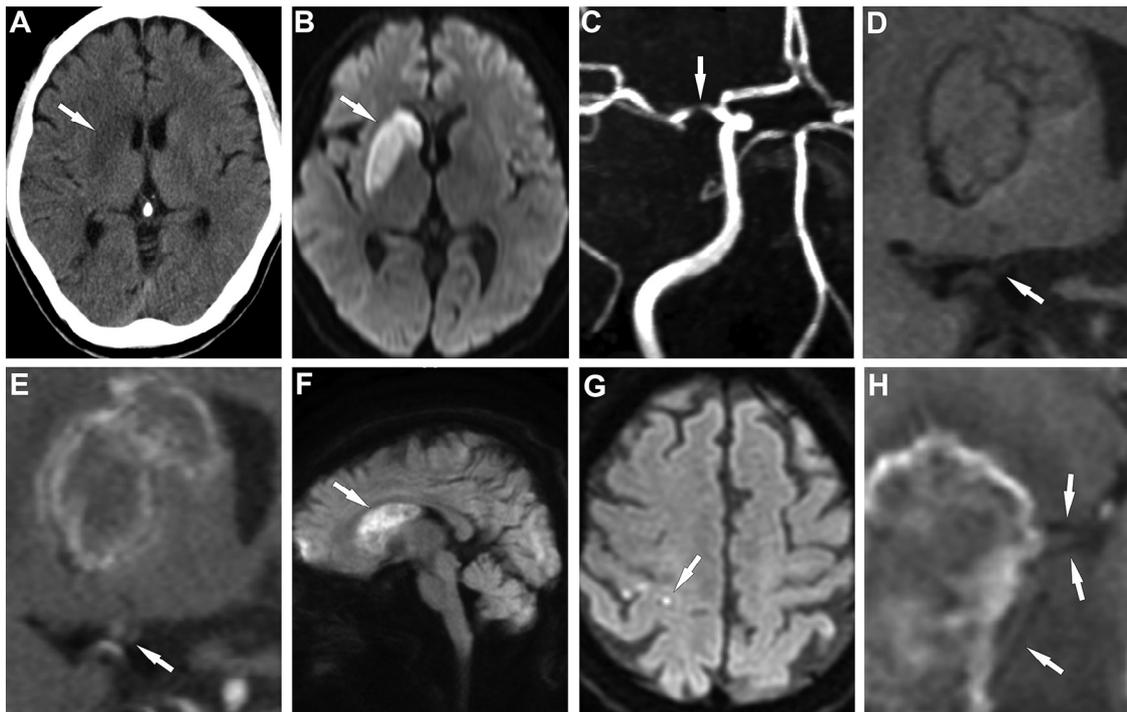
(A) Computed tomography scan showing a hypodensity signal in the right basal ganglia (white arrow). (B) Magnetic resonance imaging showed a hyperintense signal in the right lenticulostriate artery (white arrow). (C) Magnetic resonance imaging showing severe stenosis at the proximal segment of the right middle cerebral artery (white arrow). (D) Coronal Cube T1-weighted HR-MRI showed equal plaque signal in the middle cerebral artery stenosis (white arrow). (E) Enhanced Cube T1-weighted HR-MRI showing irregular enhancement of the atheromatous plaque (white arrow). (F) Sagittal diffusion-weighted imaging showing the infarction extending from the basal ganglia to the deep area. Basal ganglia appeared as hemorrhagic transformation (white arrow). (G) Diffusion-weighted imaging showing several small infarction lesions in the right parietal cortex (white arrow). (H) Sagittal Cube T1-weighted HR-MRI showing several penetrating arteries extending from the plaque of the middle cerebral artery to the infarct region (white arrows). Abbreviation: HR-MRI, high-resolution magnetic resonance imaging.
